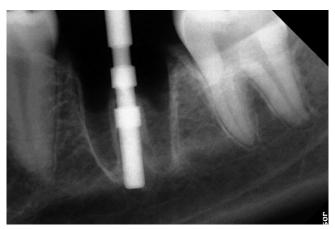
X-ray image of the guide pin in region 36.
